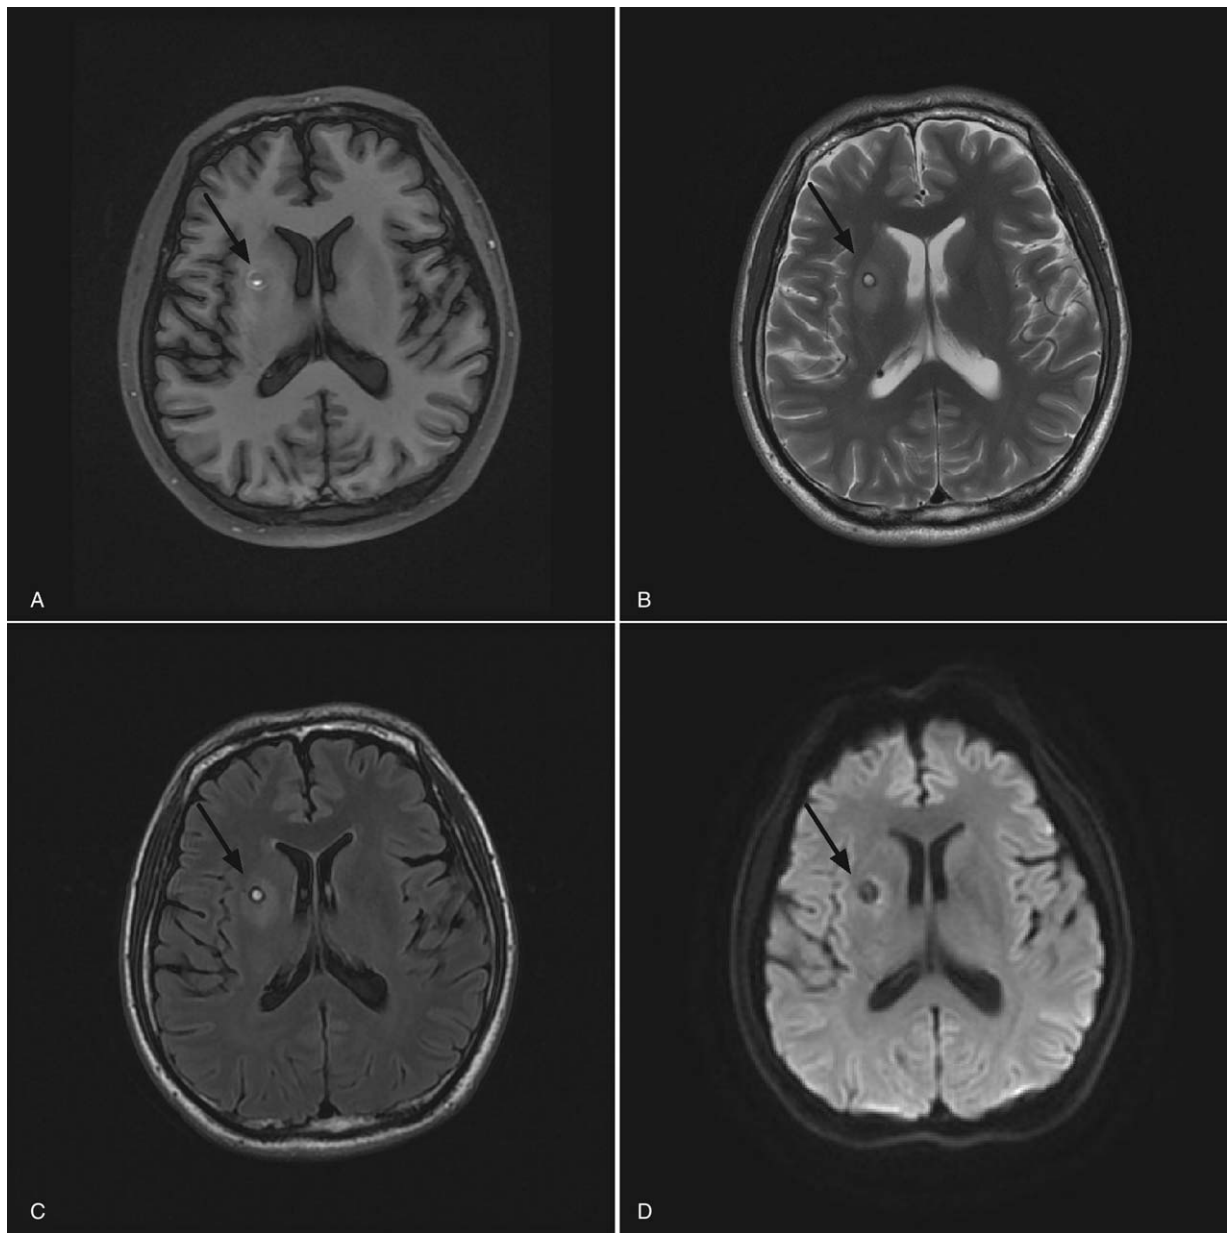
MRI at presentation showed a cavernous angioma and a small errhysis in the right putamen on axial T1-(A) weighted, T2-(B) weighted, and fluid-attenuation inversion recovery (FLAIR) (C) sequences. Diffusion-weighted imaging (DWI) showed no infarction (D).
